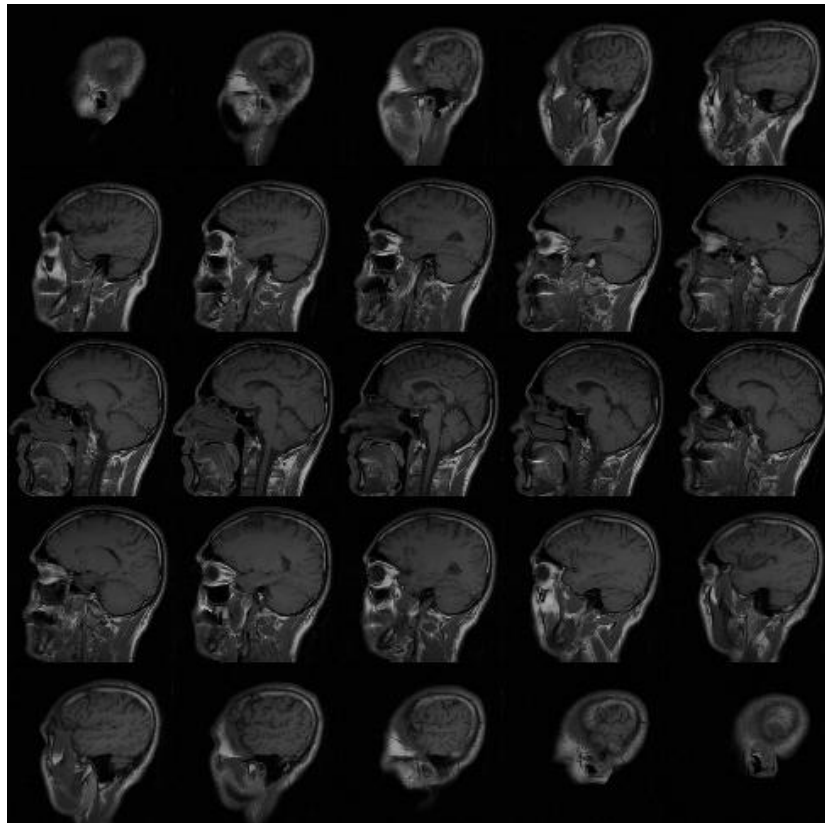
Sample T1 weighted sagittal MRI data series.
